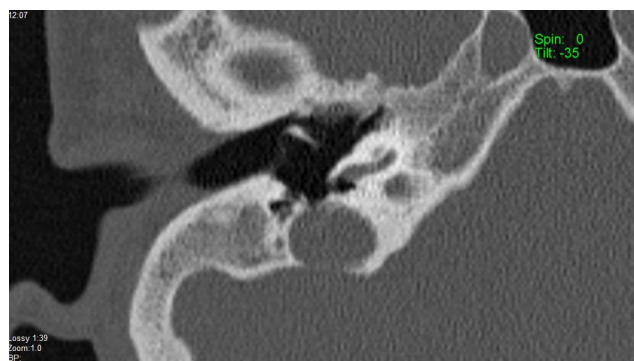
Axial computed tomography of left cochlear hypoplasia Type IV. The basal turn is normal, but the middle and apical turns are smaller than in a normal cochlea.
